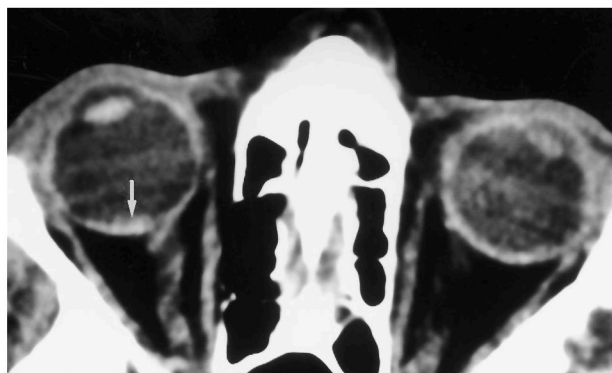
Case 4: 42-year-old man after aneurysmal rupture and clipping in the anterior communicating artery. Physical examination revealed vitreous and retinal hemorrhage in the right eye. A CT scan obtained 1 week after intracranial hemorrhage revealed a hyperdense crescent (*arrow*) on the temporal retinal surface adjacent to the optic nerve corresponding to hemorrhage on fundoscopy. Note the apparent increased density of the normal left vitreous as compared with the abnormal right side.
